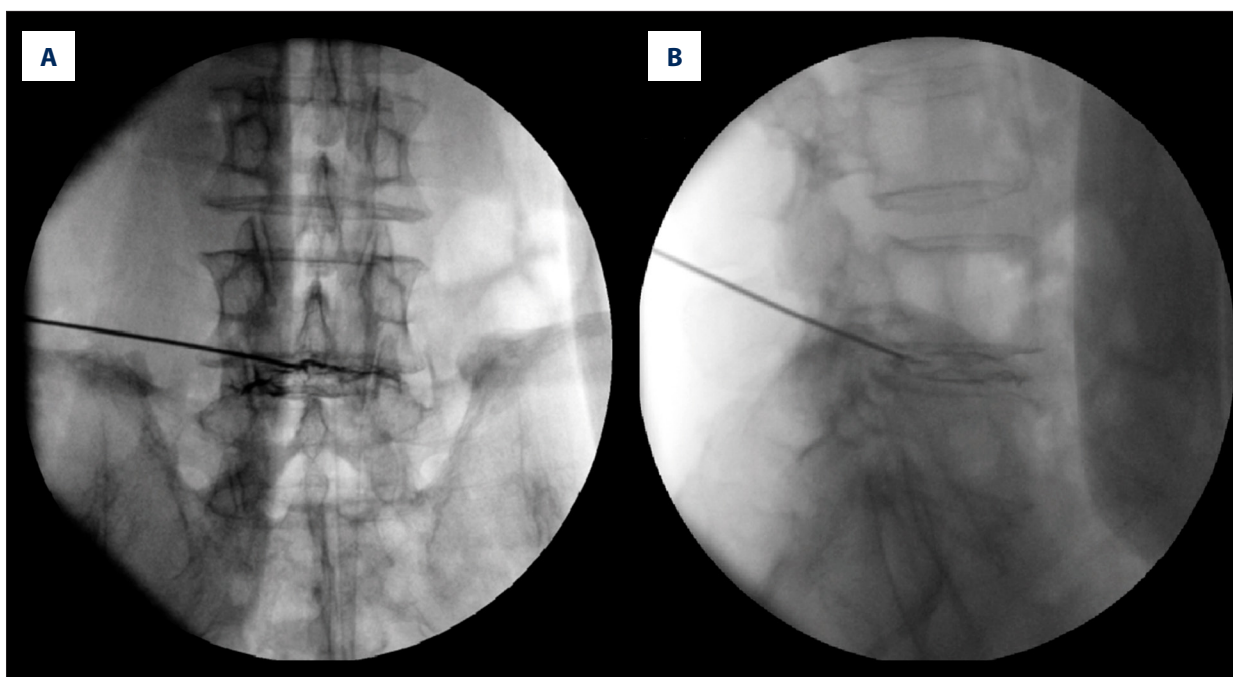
Anteroposterior (A) and lateral (B) x-ray film showing needle position of transforaminal endoscopic spine system procedure performed with posterolateral approach.
